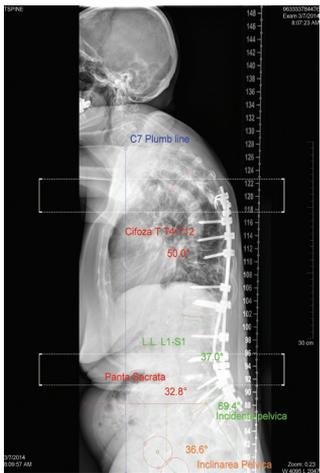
Preoperative lateral standing view X-Ray with sagittal balance.
